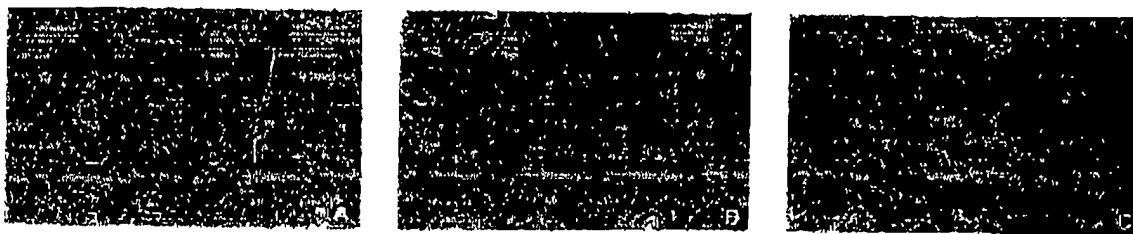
PSMA expression with the anti-PSMA mAb 7E11. (A) Benign prostate tissue, (B) primary prostate cancer, and (C) metastatic prostate cancer.
